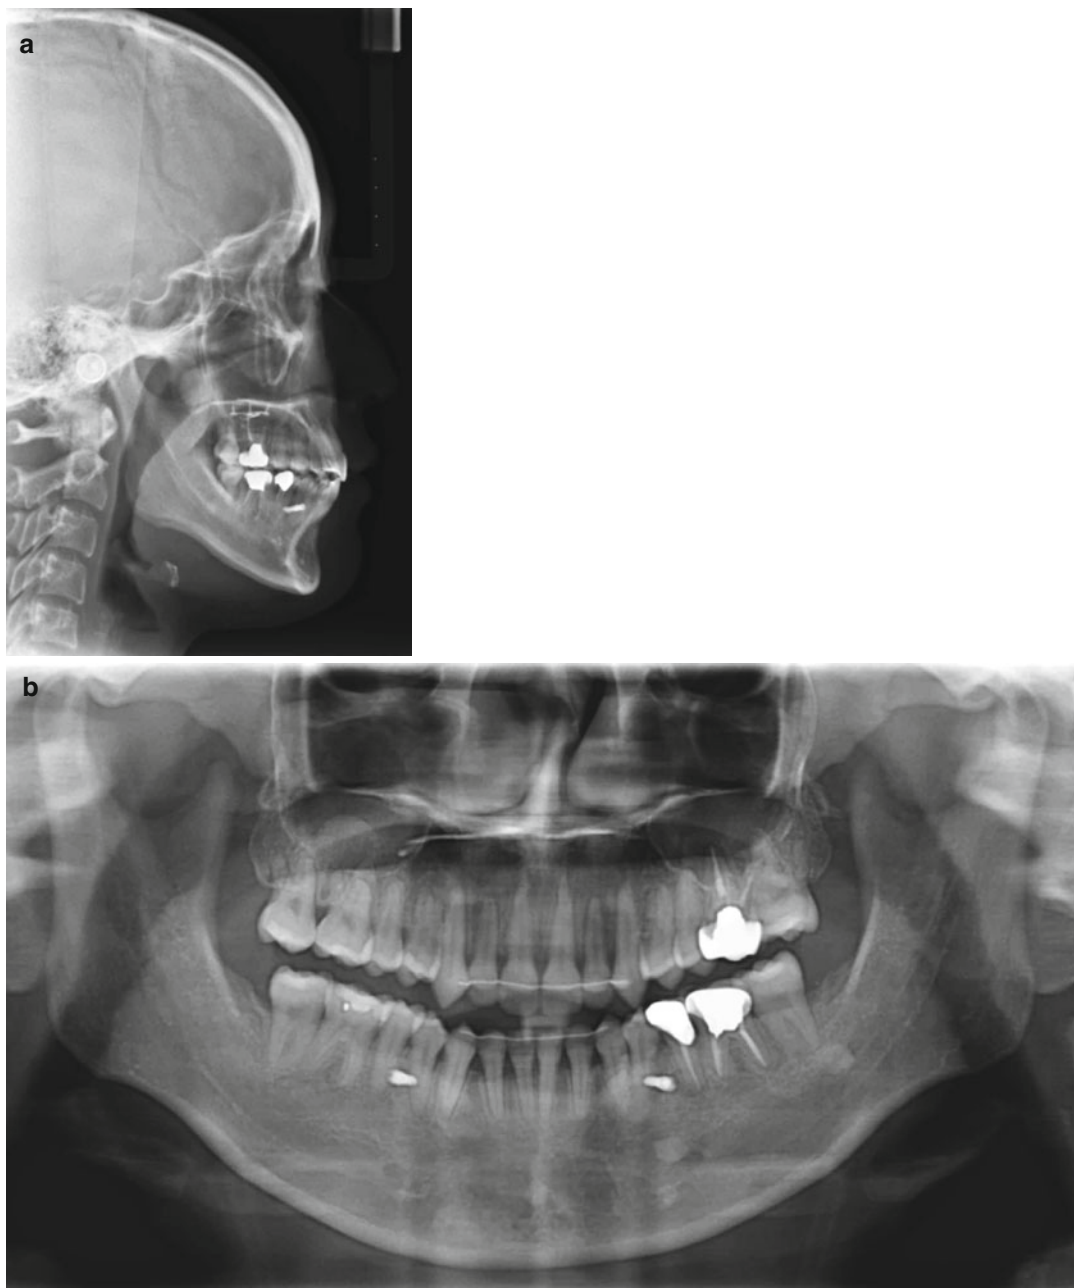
Final lateral cephalogram (a) and panoramic radiograph (b)
